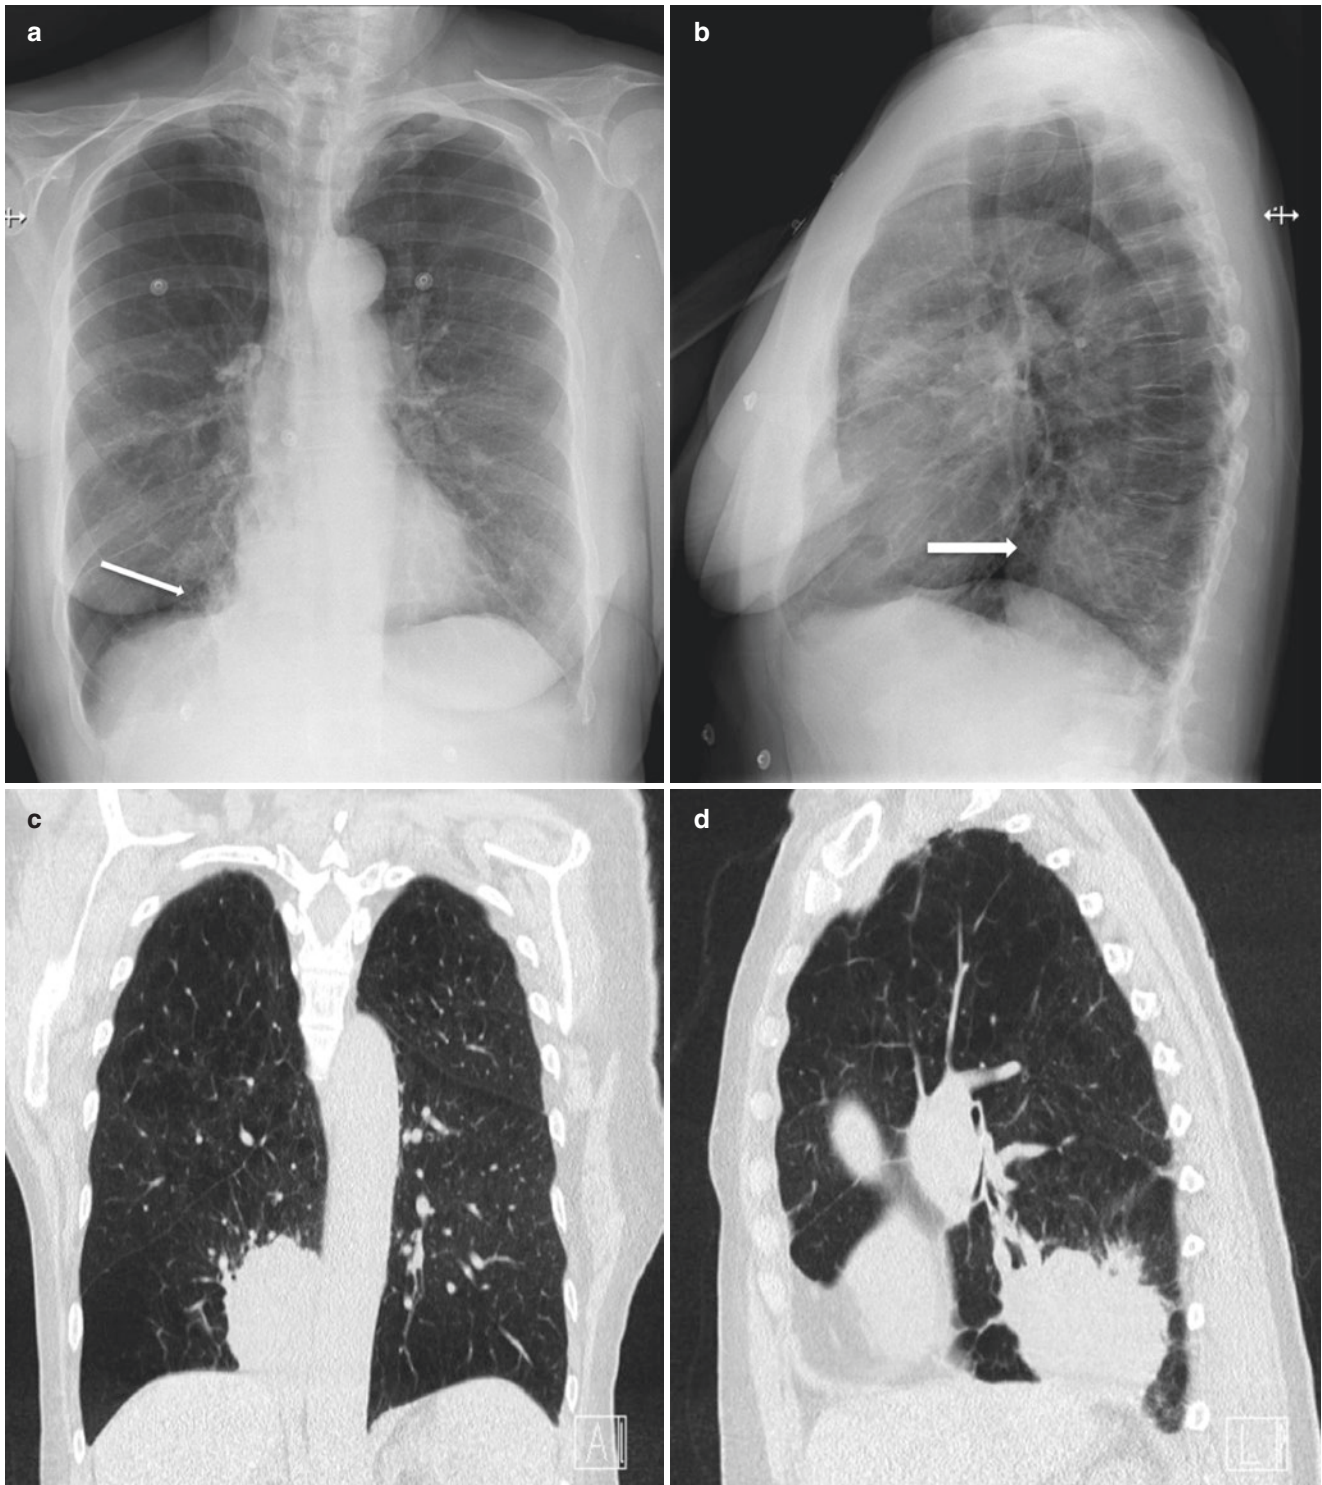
A 69-year-old woman with COPD and haemoptysis. Postero-anterior chest radiograph (a) showing an opacity next to the right border of the heart (arrow) and obliterating the right side of the spine. This silhouette sign of the right posterior mediastinal border indicates that the lesion is in a posterior location in the right lower lobe. Lateral view (b) showing an increased density (arrow) of the lower spine compared
